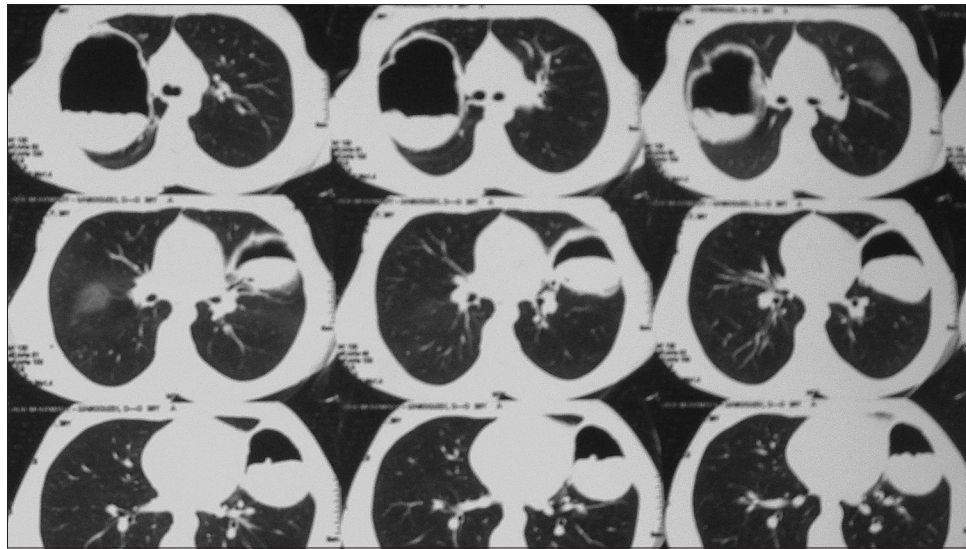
CT scan of the patient showing giant ruptured hydatid cysts of the right lung and air fluid level with water-lily sign in both ruptured hydatid cysts
